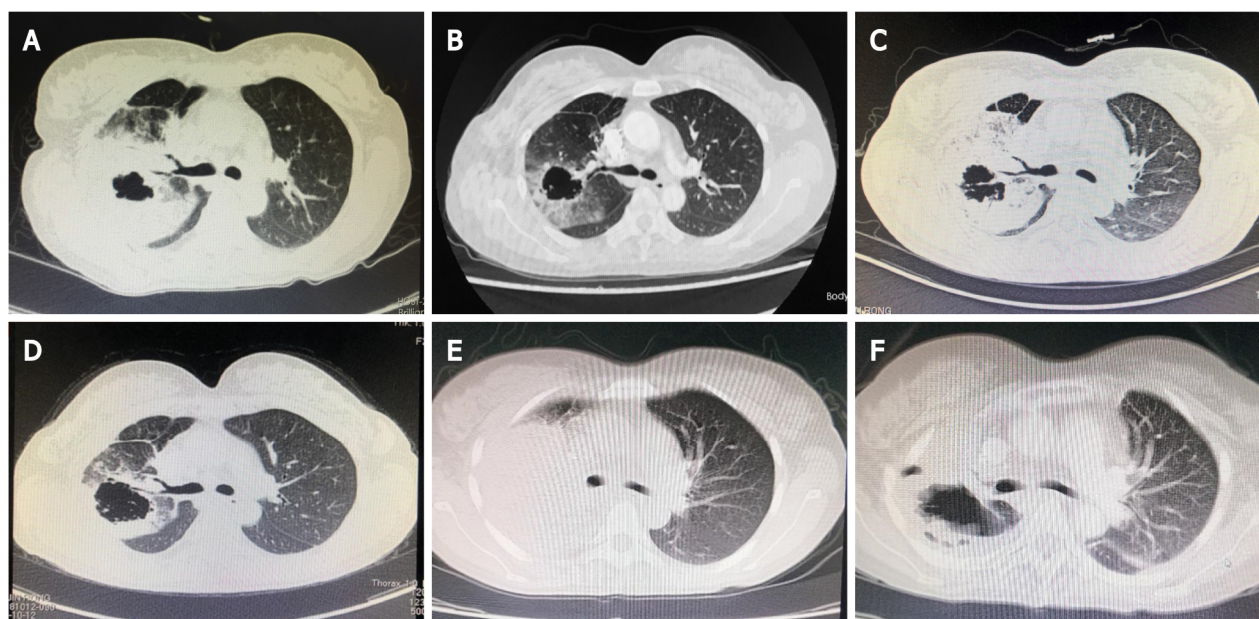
Computed tomography of the lung. A: First computed tomography (CT) scan showing thickening of the upper right lobe cavity (October 9, 2017); B: Figure showing reduction of the tumor and enlarged cavity after 4 cycles of chemotherapy (pemetrexed + cisplatin); C: Increase in tumor size 4 mo after the last chemotherapy session (June 11, 2018); D: After the patient had received radiotherapy, CT showed that the tumor began to shrink, (August 2, 2018) the tumor had reduced in size, and anlotinib was initiated (orally, 12 mg once daily from days 1 to 14 of a 21-d cycle); E: On May 1, 2019, the tumor started to enlarge but cavity enlargement was resolved; hence, nivolumab treatment was started (5 times, from May 6, 2019 to August 19, 2019); F: In August 12, 2019, the upper right lung mass was significantly smaller than that observed before the cavity enlarged.
